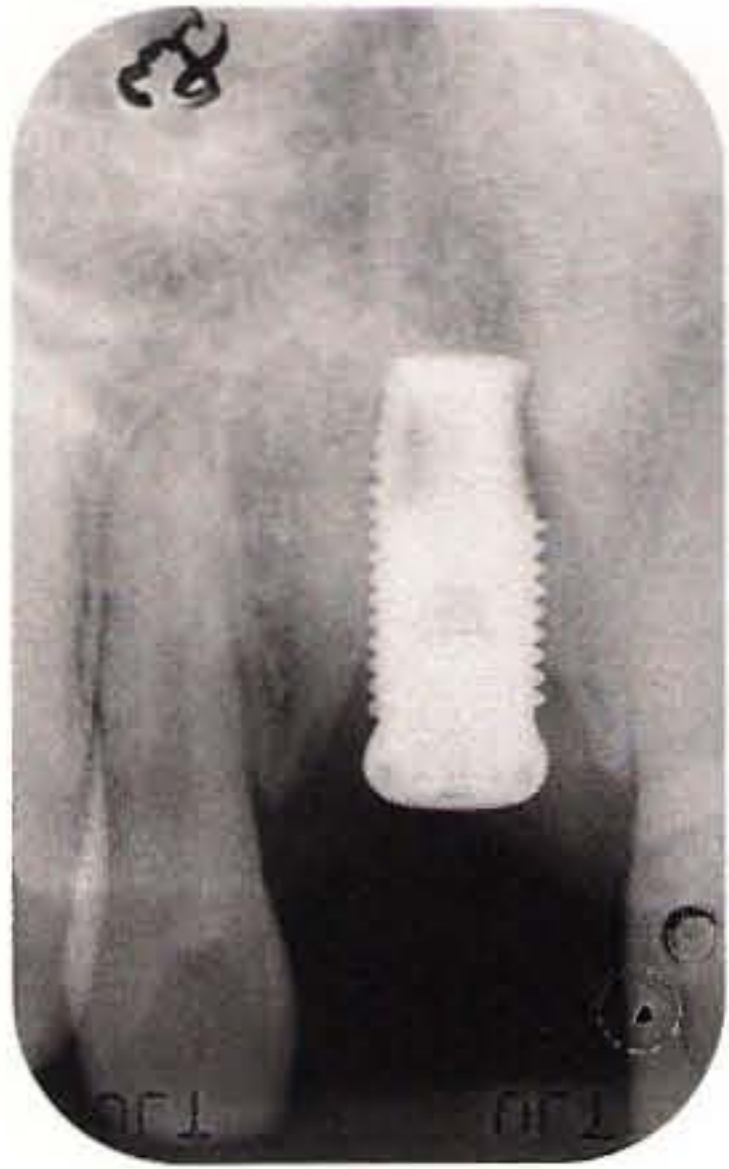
An intraoral control radiograph is taken after 6 months.
